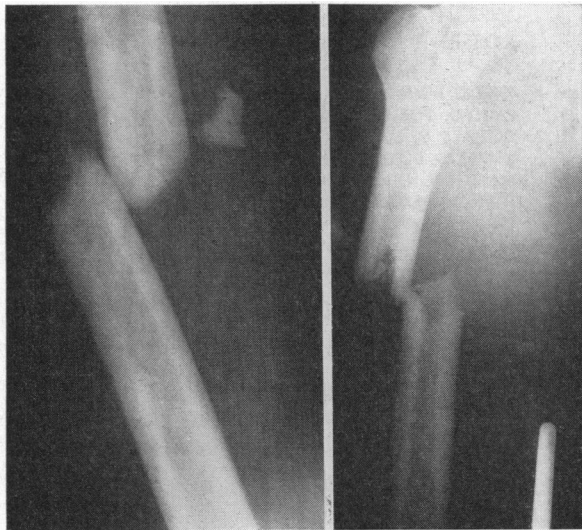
X-ray film showing fractures of left and right femurs in present case.
